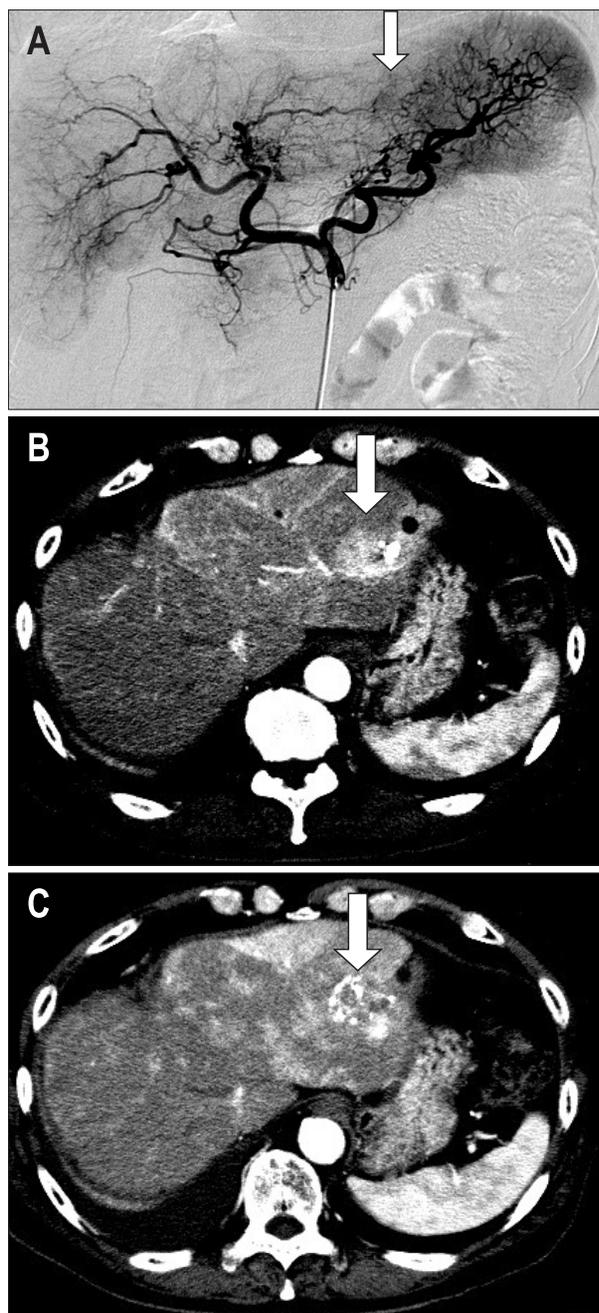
Case 1. A 72-year-old man with unresectable hepatocellular carcinoma (HCC) who received transcatheter arterial chemoembolization (TACE) with miriplatin. (A) Abdominal angiography showed multiple HCCs (arrow). (B) Computed tomography (CT) showed multiple HCCs (arrow). (C) CT performed 1 month after TACE. The lesions revealed accumulations of lipiodol (arrow). Treatment efficacy was assessed as a partial response.
